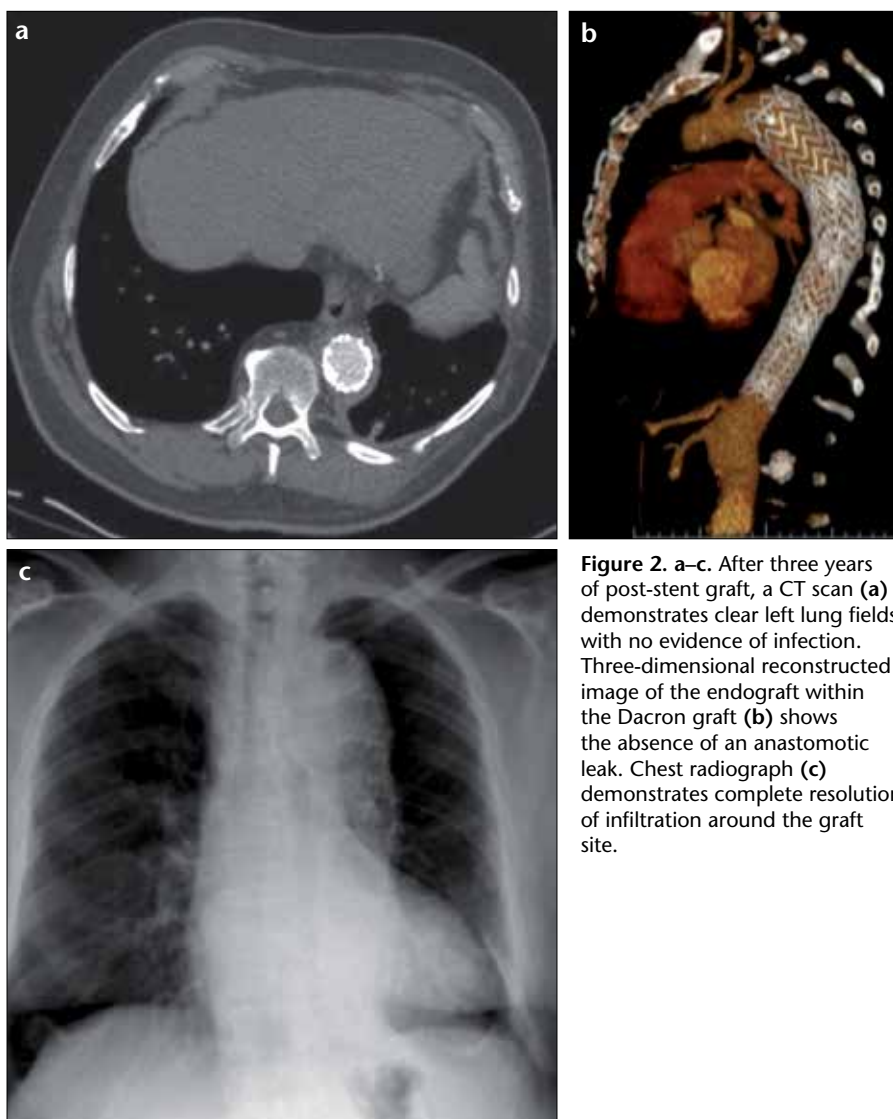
a–c. After three years of post-stent graft, a CT scan (a) demonstrates clear left lung fields with no evidence of infection. Three-dimensional reconstructed image of the endograft within the Dacron graft (b) shows the absence of an anastomotic leak. Chest radiograph (c) demonstrates complete resolution of infiltration around the graft site.
